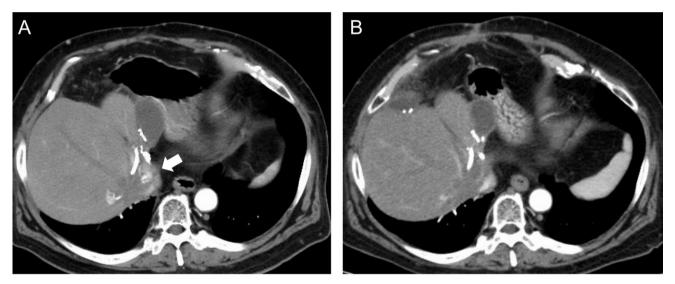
Contrast-enhanced computed tomography. (A) Pre-treatment contrast-enhanced computed tomography (CT) and (B) post-treatment contrast-enhanced CT images obtained 14 months after the completion of stereotactic body radiotherapy (SBRT) consisting of 40 Gy in 8 fractions. The target volume (arrow) completely disappeared after SBRT.
